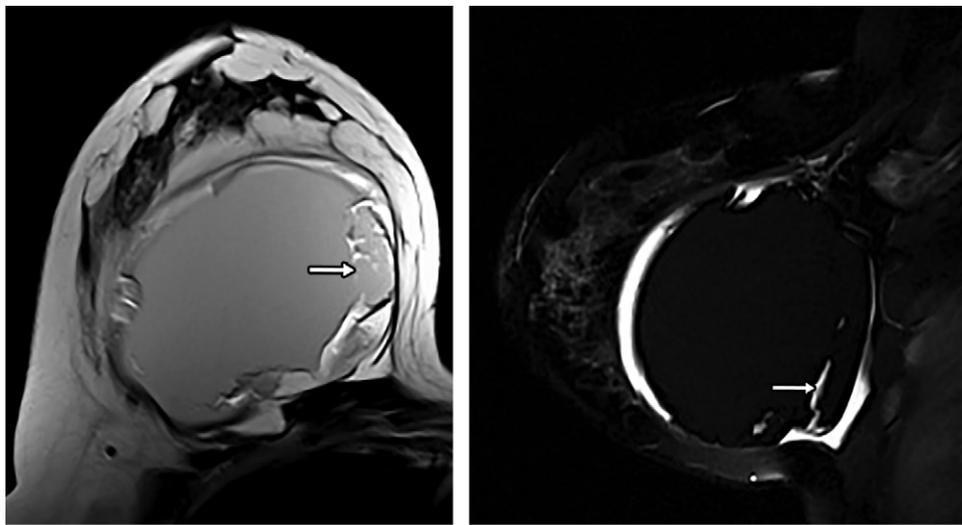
Rupture of a cohesive silicone implant. Axial T2-weighted (a) and sagittal STIR (b) MR images of the right breast show fracturing (arrow) of the semisolid gel of a cohesive (“gummy bear”) implant.
